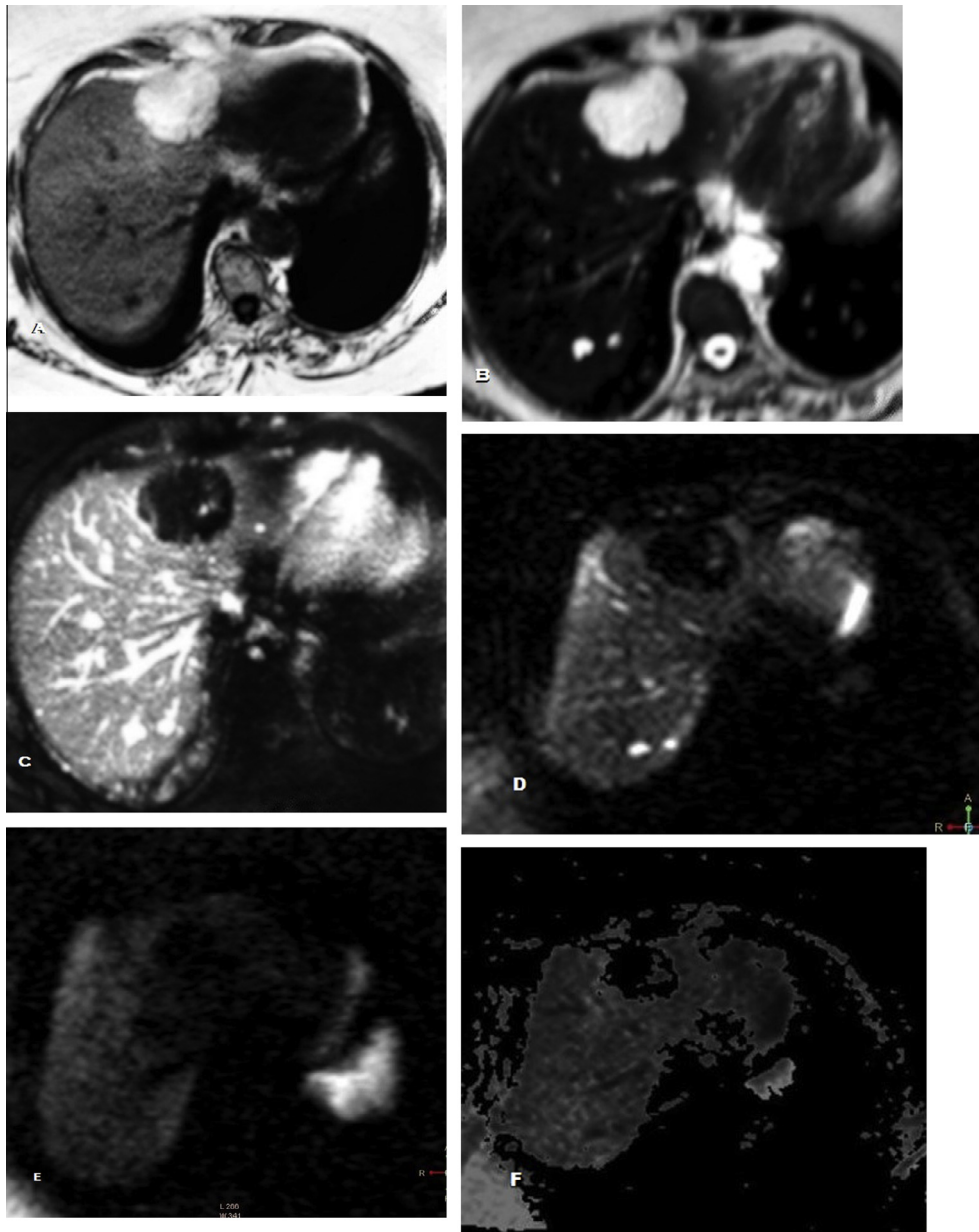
MR imaging of lipoma in a 62 years old patient. (A) Axial T1GE reveals well defined hyperintense focal lesion in segment IV of Lt lobe. (B) Axial T2 reveals well defined less hyperintense lesion in segment IV of Lt lobe and another two small lesions in segment VII of the Rt lobe. (C) Axial STIR reveals hypointense focal lesion. (D) Diffusion weighted echo planar image with $b = 0$ shows that the lesion shows signal void. (E) Diffusion weighted echo planar image with $b = 1000$ shows that the lesion maintains signal void. (F) ADC map of the lesion reveals signal void. ADC value of the lesion is low $0.1 \times 10^{-3} \text{ mm}^2/\text{s}$.
